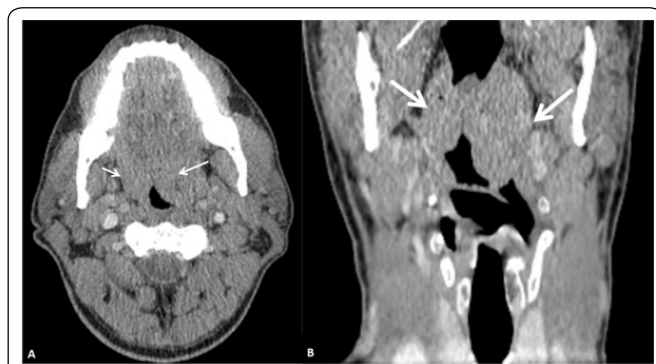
Neck CT acquisition at the axial plane (A) and reconstruction at coronal plane (B), after iodinate contrast administration, depicts a left palatine tonsil solid mass, with mild and homogeneous enhancement, and a similar smaller mass at the right palatine tonsil (arrows), with decrease of the airway caliber.
